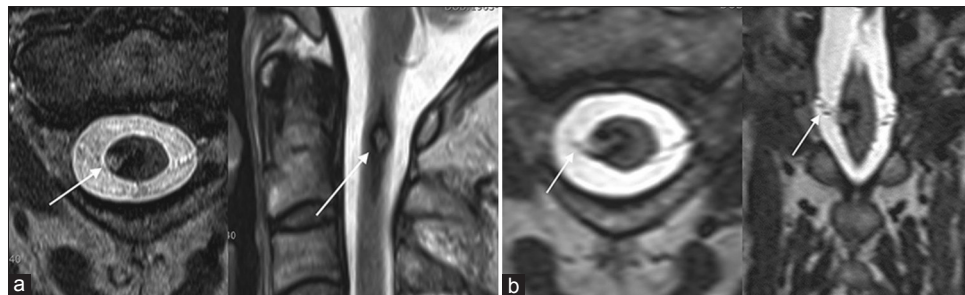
Magnetic resonance imaging findings of occipital neuralgia associated with cavernous hemangioma. (a) T2-weighted axial and sagittal images showing a reticulated core of high signal intensity with a surrounding rim of decreased signal intensity (arrow) indicating the presence of hemosiderin, thus suggesting the diagnosis of cavernous malformation. (b) Axial and coronal multiplanar reconstruction images showing the relationship between the cavernous malformation and C2 rootlets (arrow). Note the location of cavernous malformation at the right posterolateral C1-2 cord segment suggesting involvement of the dorsal horn, the dorsal root entry zone, and the caudalis trigeminal nucleus of C2. Characteristically, the dorsal root of C2 directly attached to the cavernous malformation (arrow)
